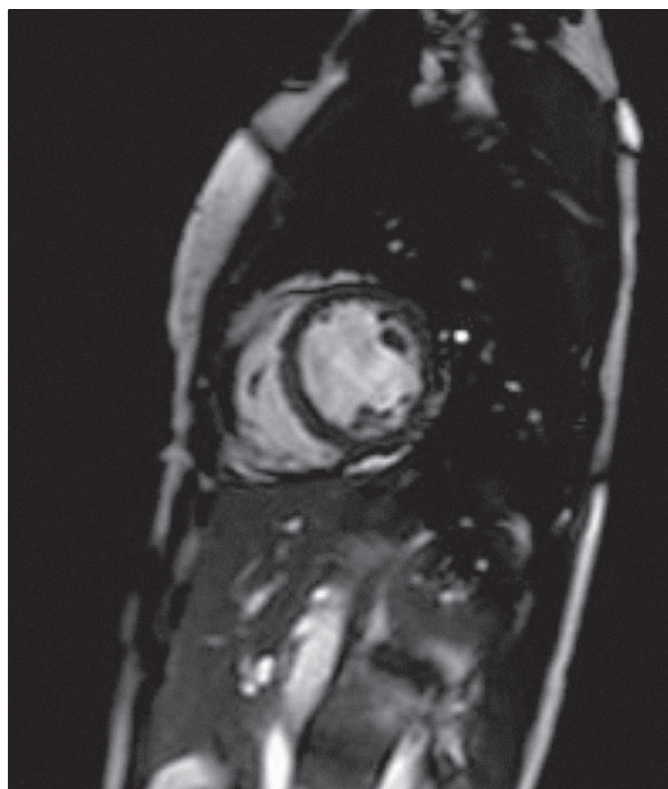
MRI: global left ventricular hypokinesia with depressed ejection fraction of 40 %, without late gadolinium enhancement.
